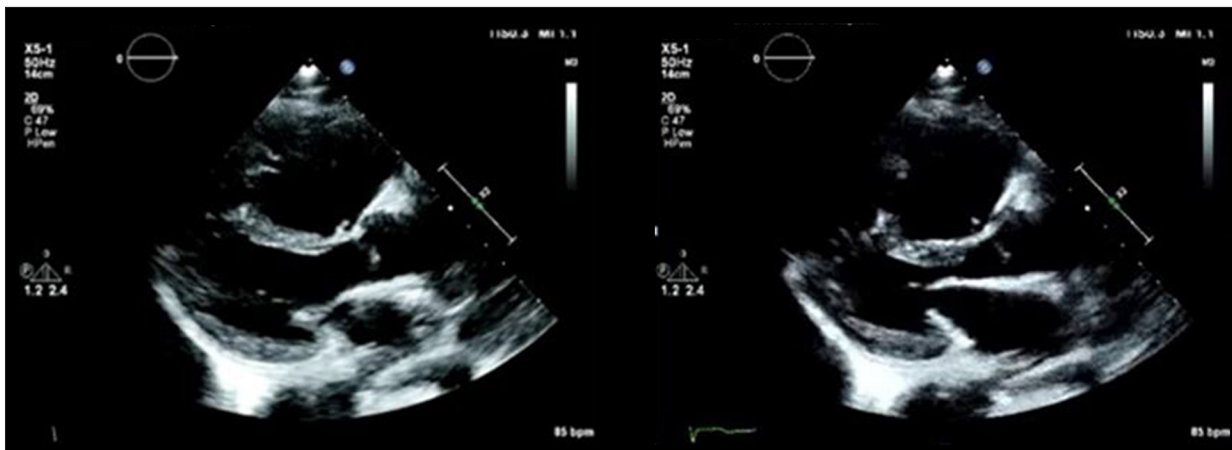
Transthoracic echocardiogram of the left and right ventricles. The left ventricle (LV) is normal in size, and systolic function is normal. The right ventricle (RV) is dilated with reduced systolic function.
